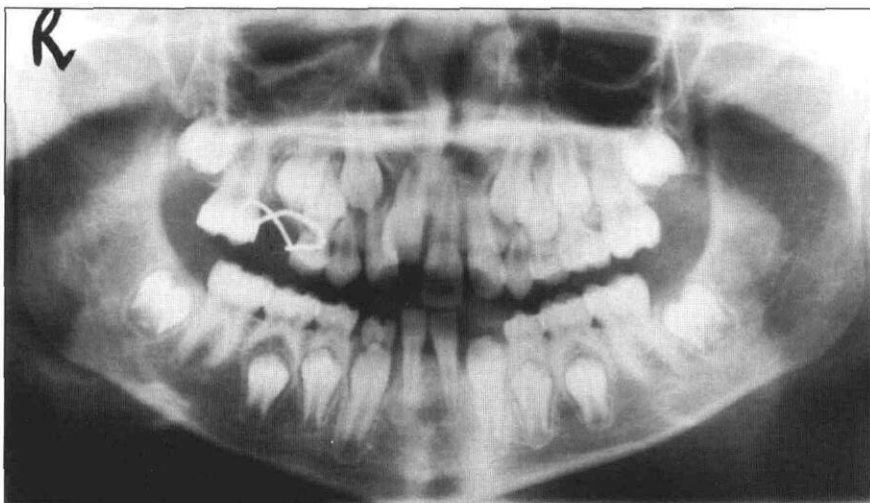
Case #2. Panoramic radiograph of the patient taken 28 months previous to that in Fig 2. The crown of the right permanent second molar was fully formed with no evidence of any defect. The patient had a mesiodens supernumerary, which was removed a year previously. The extracted maxillary right second primary molar had severely ankylosed. There was congenital absence of two mandibular permanent incisors.
